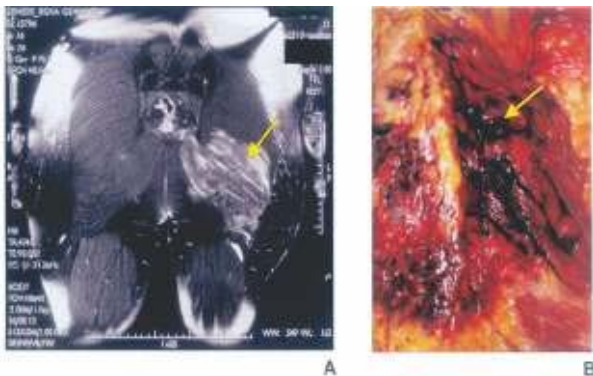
Patient deceased due to trauma caused by vehicular collision. (a) Coronal MRI slice, (b) autopsy image. Source: Taken from Thali *et al.*^[13]
